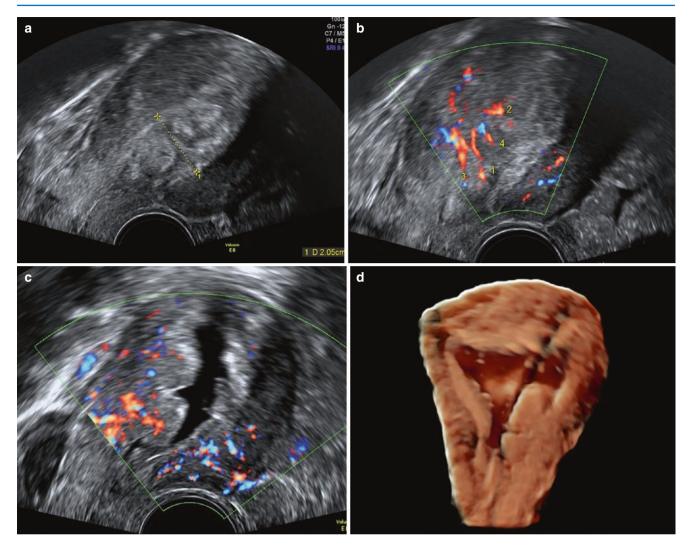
A case of cystic hyperplasia with polypoid endometrium. (a) Regular TVS – greyscale image of uterus showing thickened complex endometrium. (b) Doppler showing multiple vessels crossing the EMJ on regular TVS. (c) SHG showing fluid in the endometrial cavity and a posterior polypoidal endometrium with vascular flow. (d) SHG with 3D rendered image of the uterus showing the polypoidal endometrium along its lateral walls
